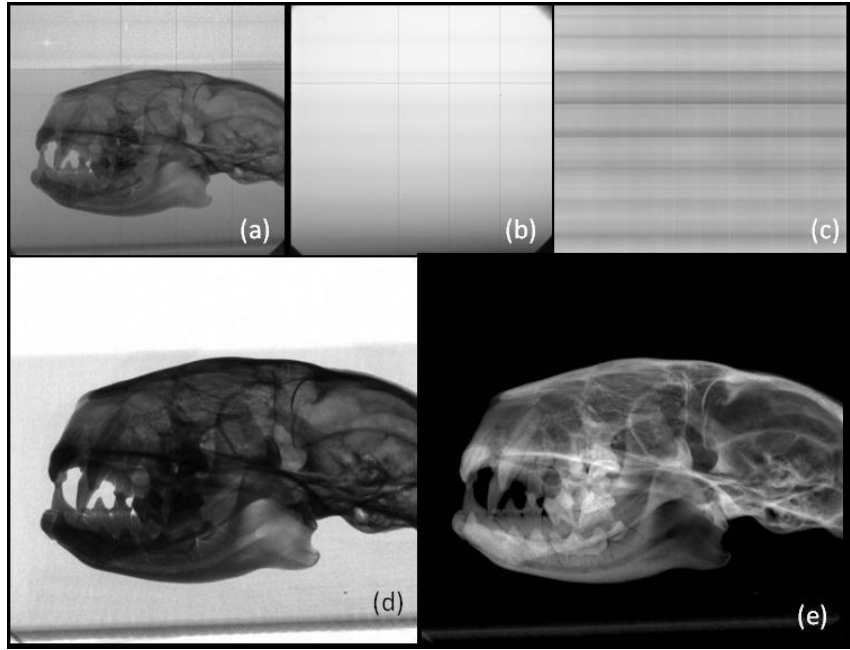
(a) N_{out} : raw data obtained at the detector, (b) N_{fill} : flood image (without the object), (c) I_{dark} : dark current image (X-ray source off), (d) $\int \mu(x)dx$: raw data obtained at the detector after correction (3.3), (e) attenuation image after applying the logarithm to (d).
